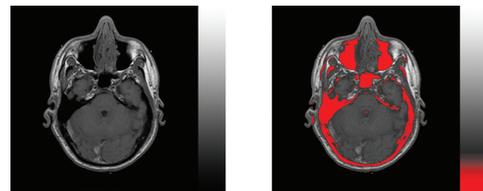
Bone tissue highlighted (red) in an MRI scan.
